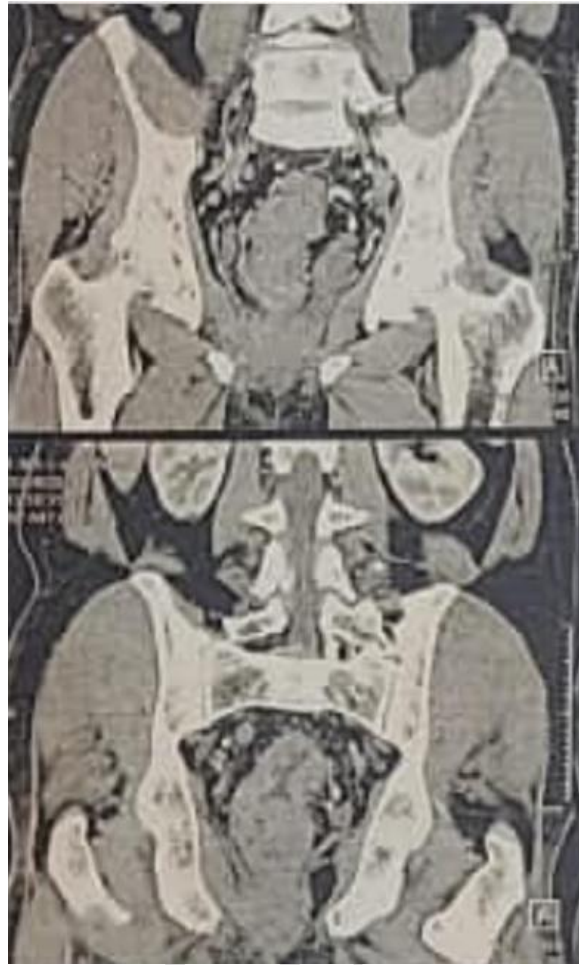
Coronal section CT scan showing circumferential, irregular, stenosing rectal parietal thickening
